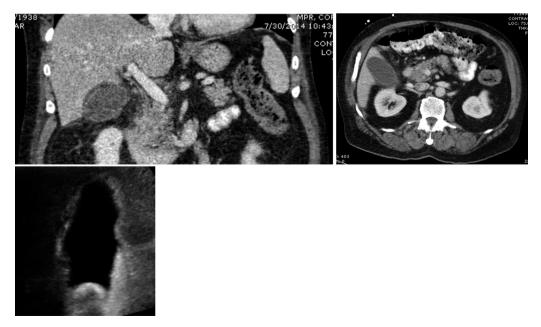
From left to right: Mr. PH, CT and ultrasound findings. #1 and #2: CT showing a distended gallbladder wall with decreased contrast enhancement of the wall and pericholecystic fluid. #3: Ultrasound showing normal mild gallbladder wall thickening with irregular appearance of the gallbladder.
